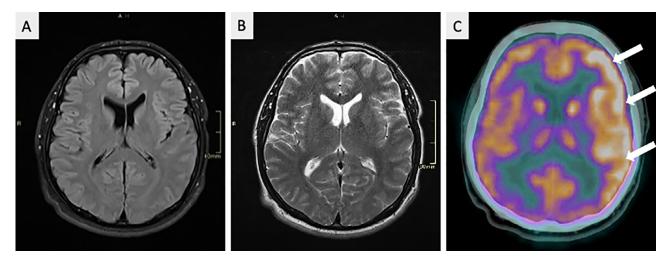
Axial brain MRI images showing no abnormalities on (A) FLAIR (Fluid attenuated inversion recovery) and (B) T2-weighted sequences with (C) corresponding left sided abnormalities on FDG-PET scan slice (white arrows).
